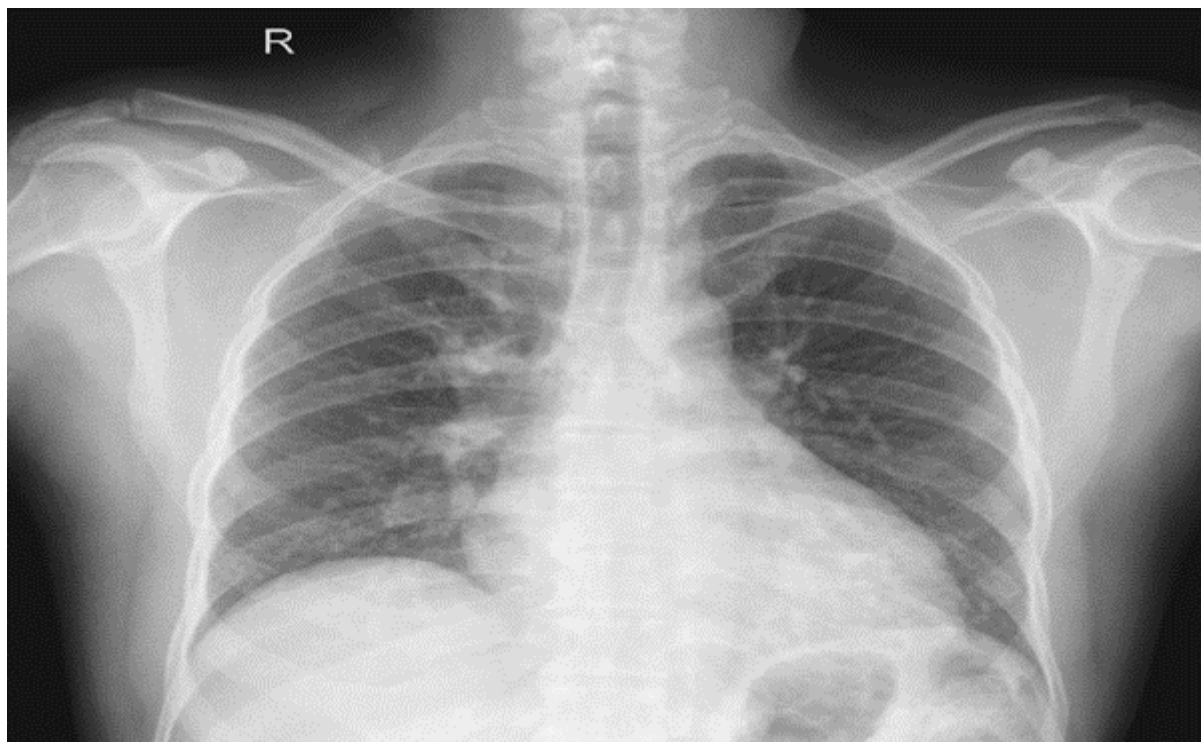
X-ray following antibiotic treatment.
